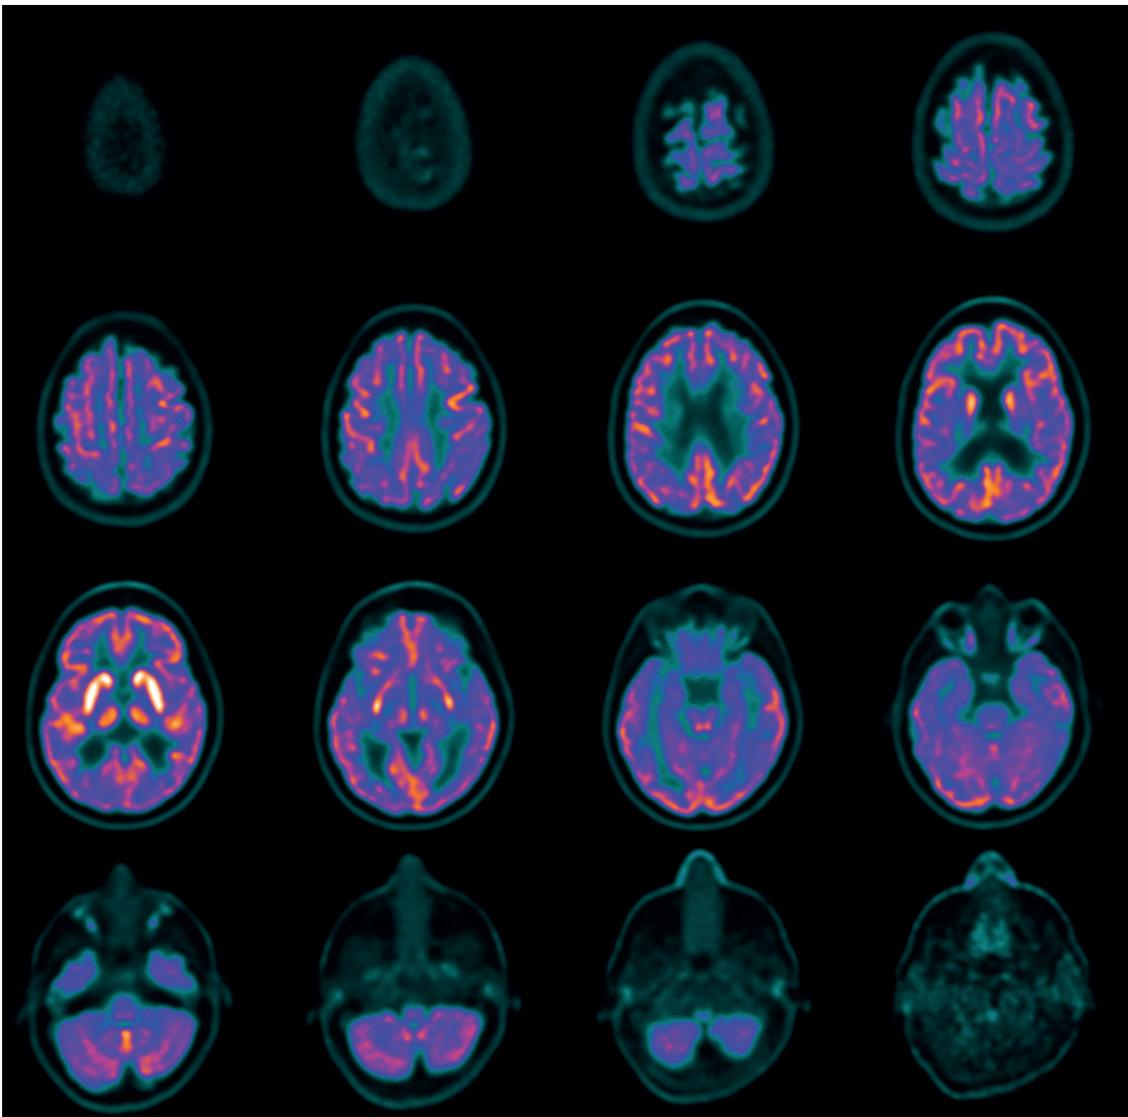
Typical ^{18}F FDG-PET pattern of HIV infection with HIV-associated neurocognitive disorder (HAND): global irregular ^{18}F FDG hypometabolism in cortical areas associated to a high tracer uptake in subcortical regions, especially in basal ganglia.
